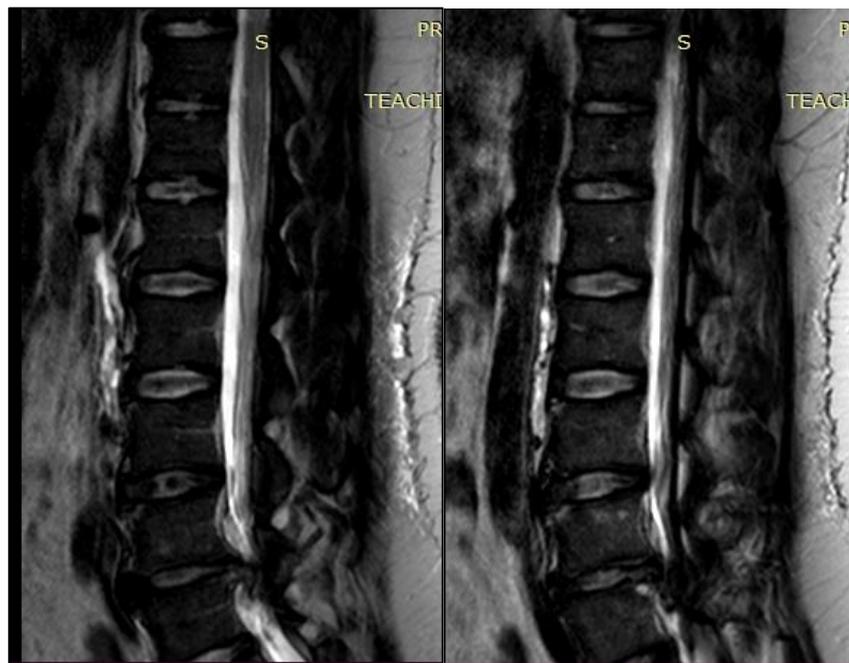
MRI showing cauda equina compression
